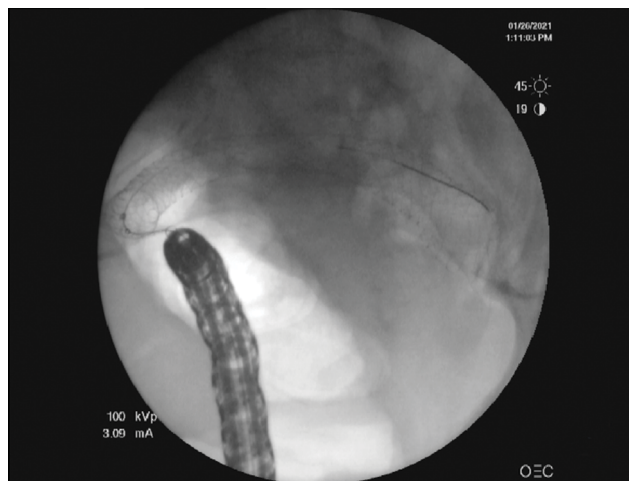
Abdominal radiography confirming the position of the SEMS.
